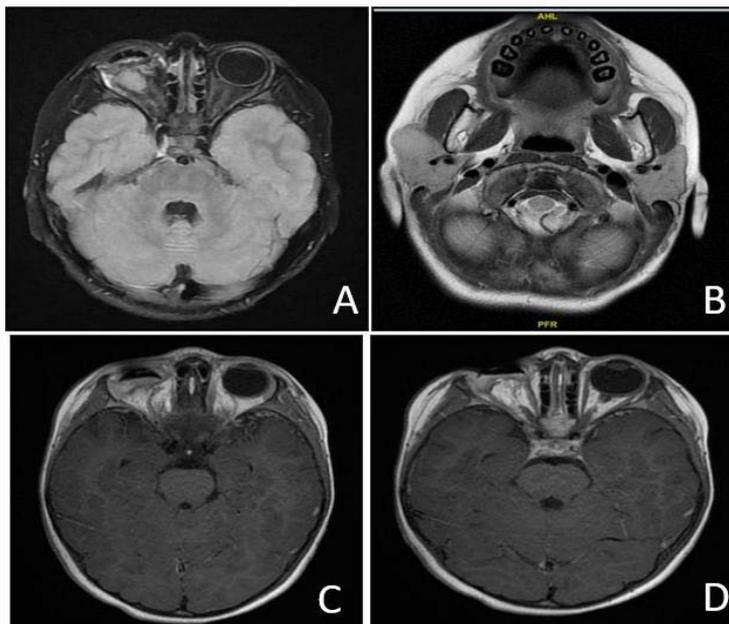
A and B) MRI of the brain January 2021 (T2 with contrast). C and D) MRI of post-surgical brain June 2021 (T1 c/c).
